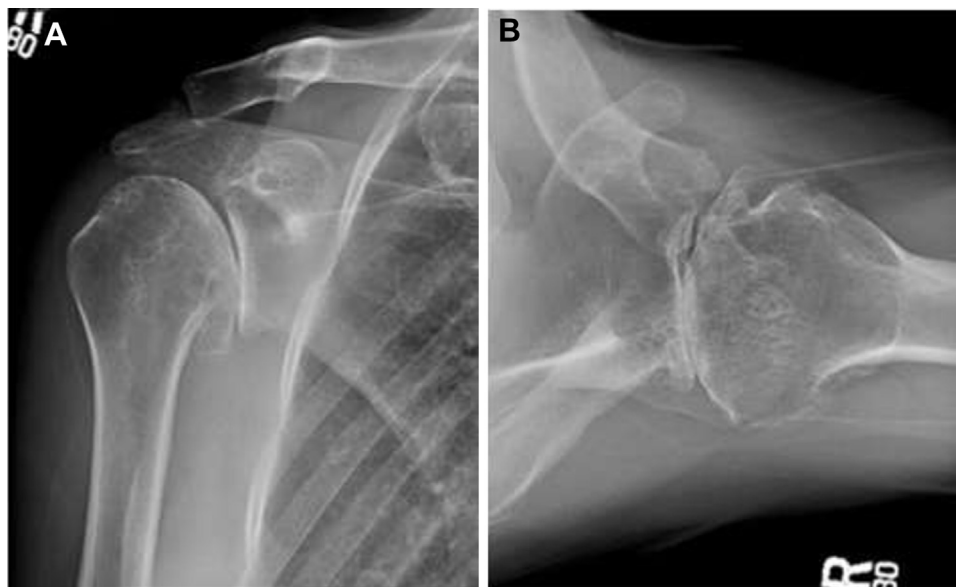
(A) Preoperative true AP X-ray of the *right* glenohumeral joint showing degenerative joint disease. (B) Preoperative axillary X-ray of the *right* glenohumeral joint showing degenerative joint disease.
